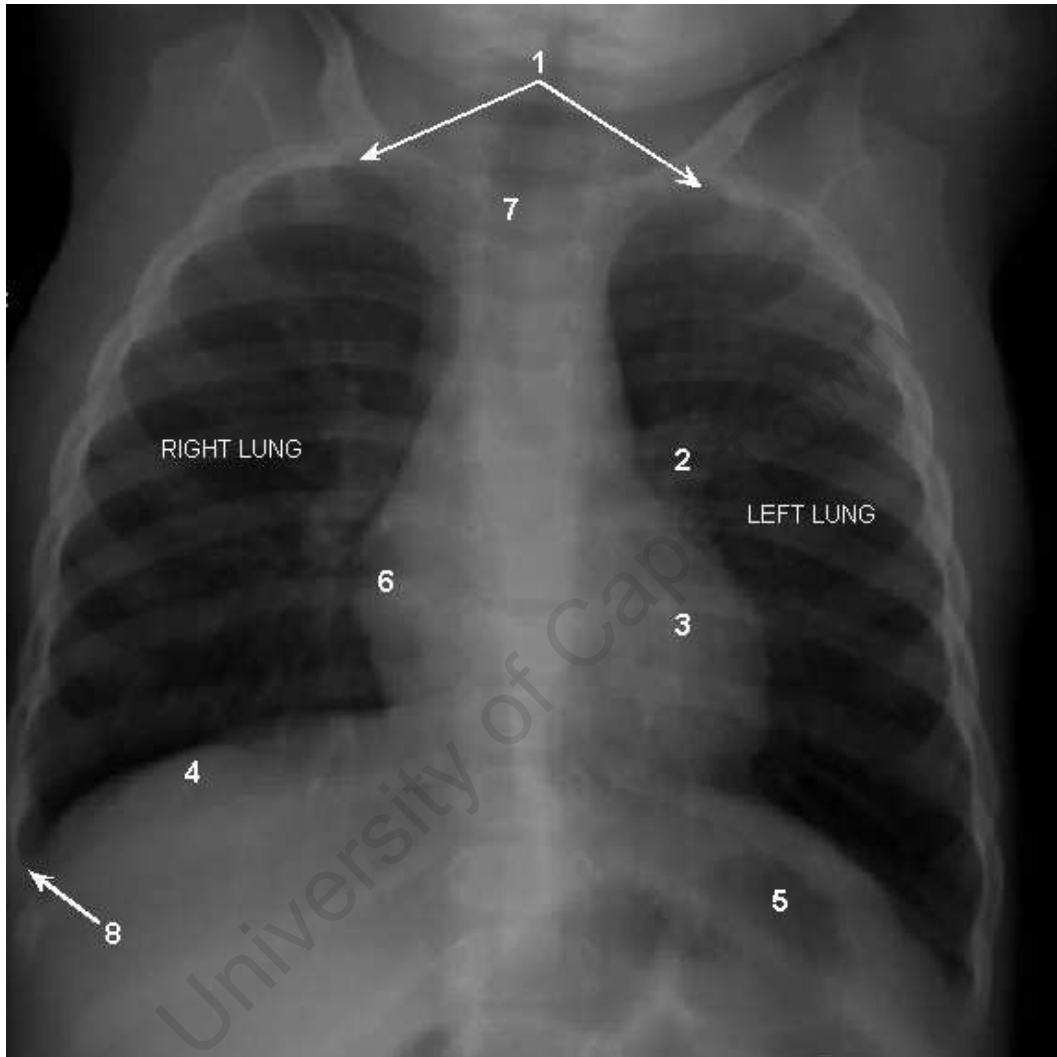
A normal anterior-posterior (AP) chest radiograph. The right lung field appears on the left side of the image. The lung fields appear black in the image. 1) The lung apices. 2) The left hilum, where the arteries, veins and bronchi enter the lung. 3) The cardiac shadow. 4) The right hemi-diaphragm begins below the lung field. 5) The left hemi-diaphragm with stomach gases (darker region) visible. 6) The right atrium. 7) The trachea. 8) The right costophrenic angle (where the diaphragm meets the ribs). The area projected between the two lung fields is the mediastinum.
